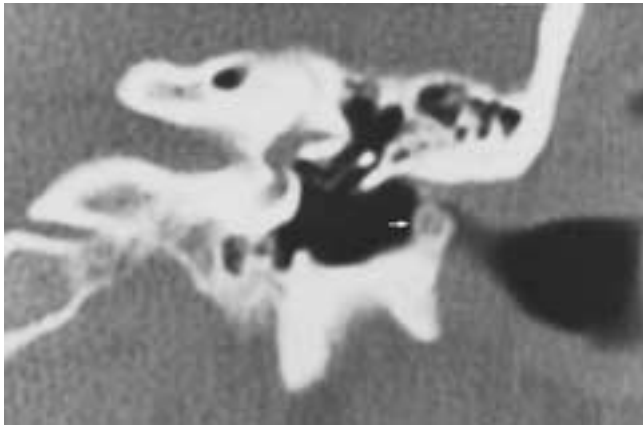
EAC osteoma. CT. Tumor typically arises at the tympanomastoid or tympanosquamosal suture (*arrow*). (Compare with Fig. 25-111.) (Courtesy of Dr. Anton N. Hasso.)
